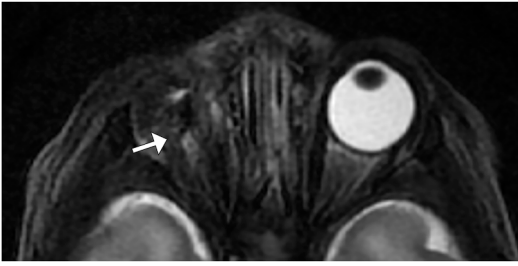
Axial T2-weighted fat-suppressed sequence demonstrates right anophthalmia with no discernible ocular tissue and a dysplastic optic nerve (*white arrow*).
